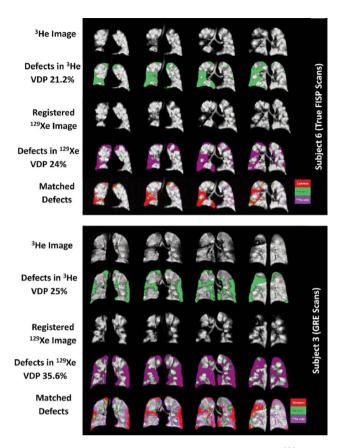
MR images demonstrating defect analysis for both  $^{129}Xe$  and  $^{3}He$  gases from two representative subjects. Top set of images (Subject 6): excellent concordance between the ventilation defects with both  $^{129}Xe$  and  $^{3}He$ ; bottom set of images (Subject 3): shows more and larger ventilation defects with  $^{129}Xe$  compared to  $^{3}He$ . MR, Magnetic resonance (23).
